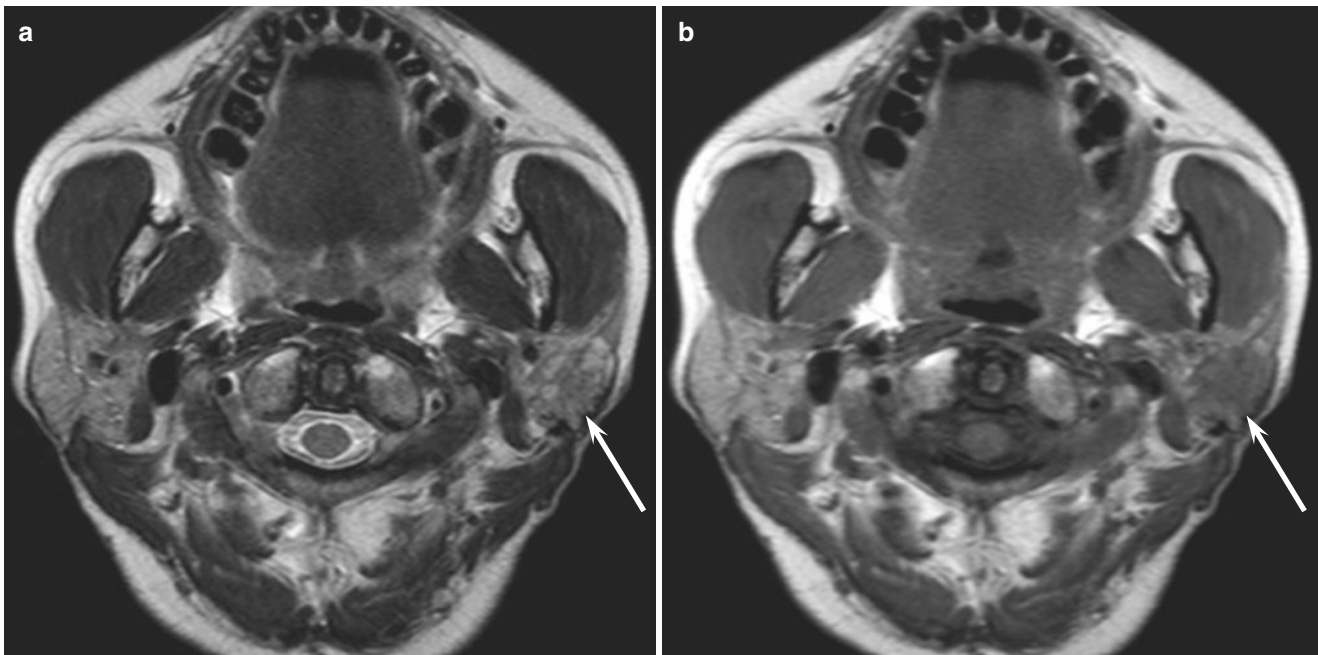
A 54-year-old woman with adenoid cystic carcinoma of the left parotid gland. (a) T2-weighted image shows an ill-defined, heterogeneously iso- to hyperintense lesion (arrow). (b) T1-weighted image shows an ill-defined, hypointense lesion (arrow)
